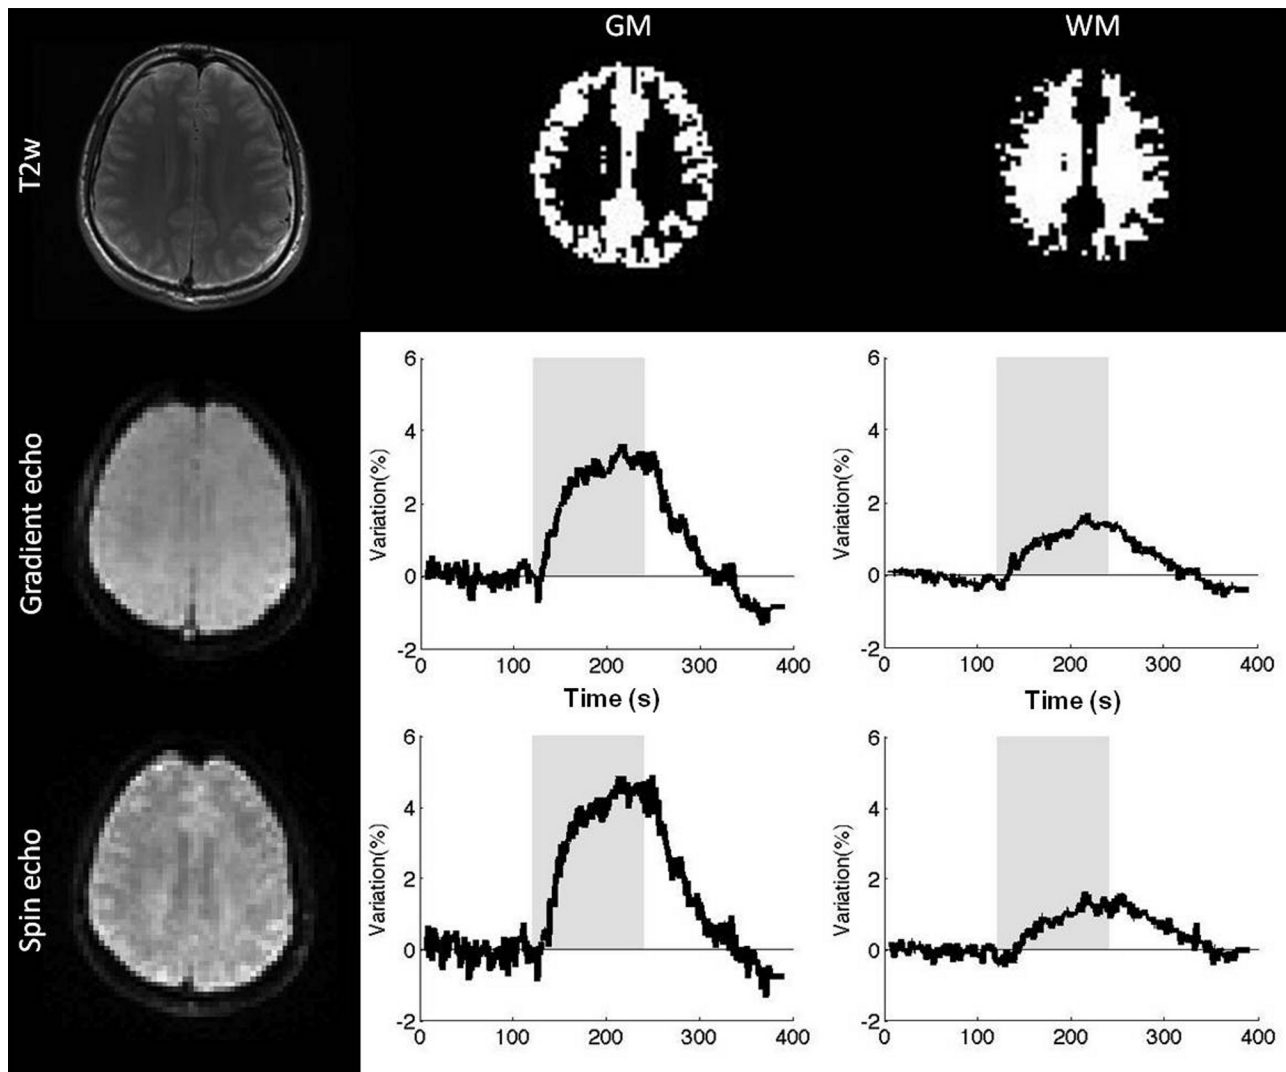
Oxygen-sensitive MR imaging in the setting of cerebrovascular challenge during a 2-minute inhalation of carbogen gas (95% O₂, 5% CO₂). Images were acquired by using a multiple spin- and gradient-echo pulse sequence that enables the measurement of T2* and T2* with high temporal resolution. Note the increase in signal corresponding to decreased T2 and T2* during carbogen inhalation (gray column).
